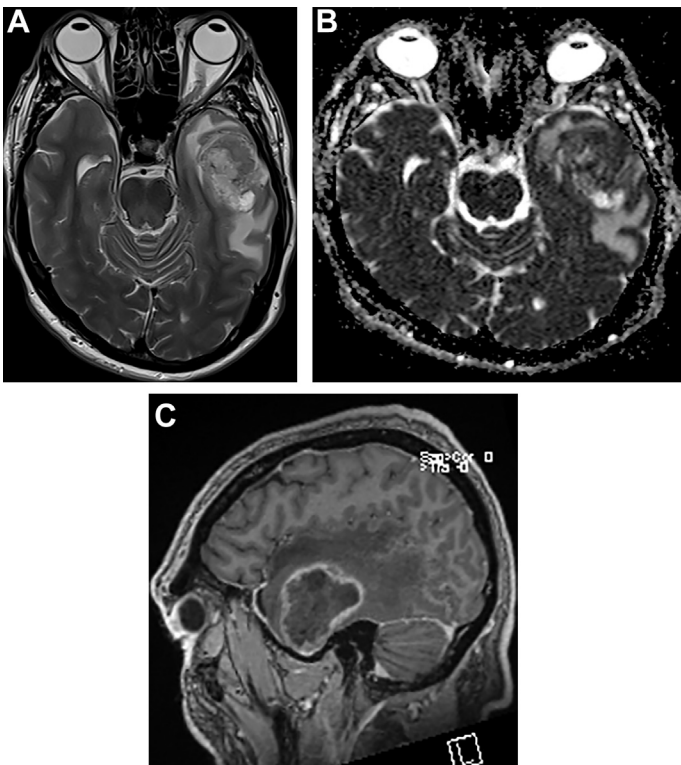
IDH wild-type glioblastoma. A 62-year-old man presented to the emergency department with right-sided numbness and difficulties with fine motor skills. Axial T2-weighted image (A) shows heterointense mass in the left temporal lobe with large perilesional T2 hyperintensity. Axial ADC image (B) shows low ADC in the soft tissue component and few cystic areas. Sagittal postcontrast T1-weighted image (C) shows a necrotic mass with peripheral enhancement.
